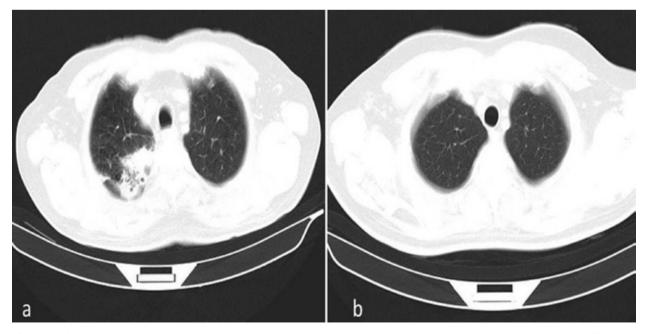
(a) Initial CT scan shows consolidation with air bronchograms in right upper lobe apical and posterior segment (COP); (b) After 4 month from initial scan, the lesions completely disappeared.
